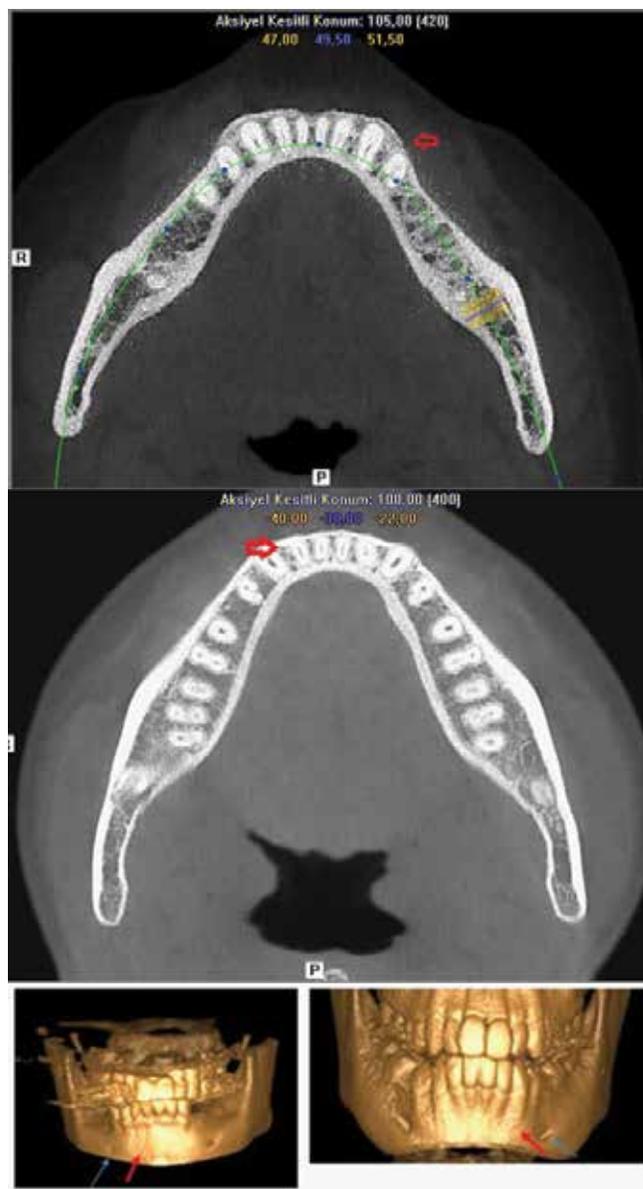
Axial and 3D CBCT images showing the MIC, which were located on the buccal plate of the anterior mandible (red arrows). Blue arrows demonstrate mental foramen.
